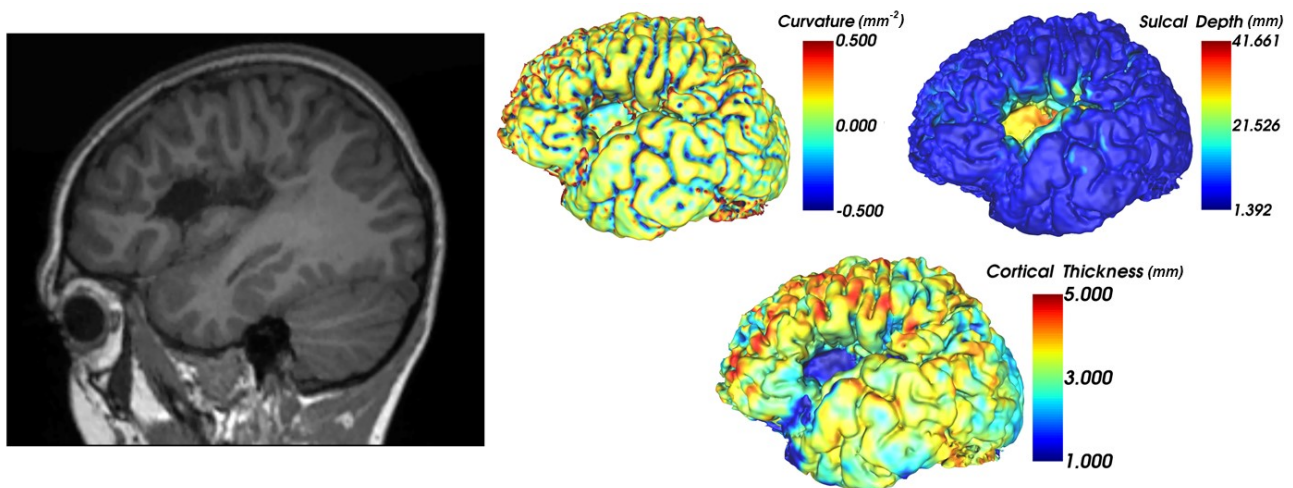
The structural MRI of a patient with a unilateral malformation, and the measured cortical thickness, curvature and sulcal depth, displayed on the VTK mesh for the injured hemisphere.
